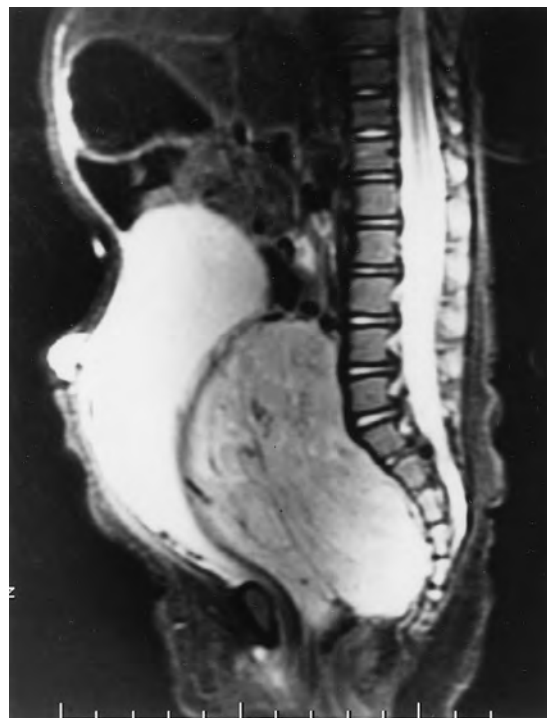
Magnetic resonance image demonstrating compression of bowel and bladder by a pelvic neuroblastoma.
